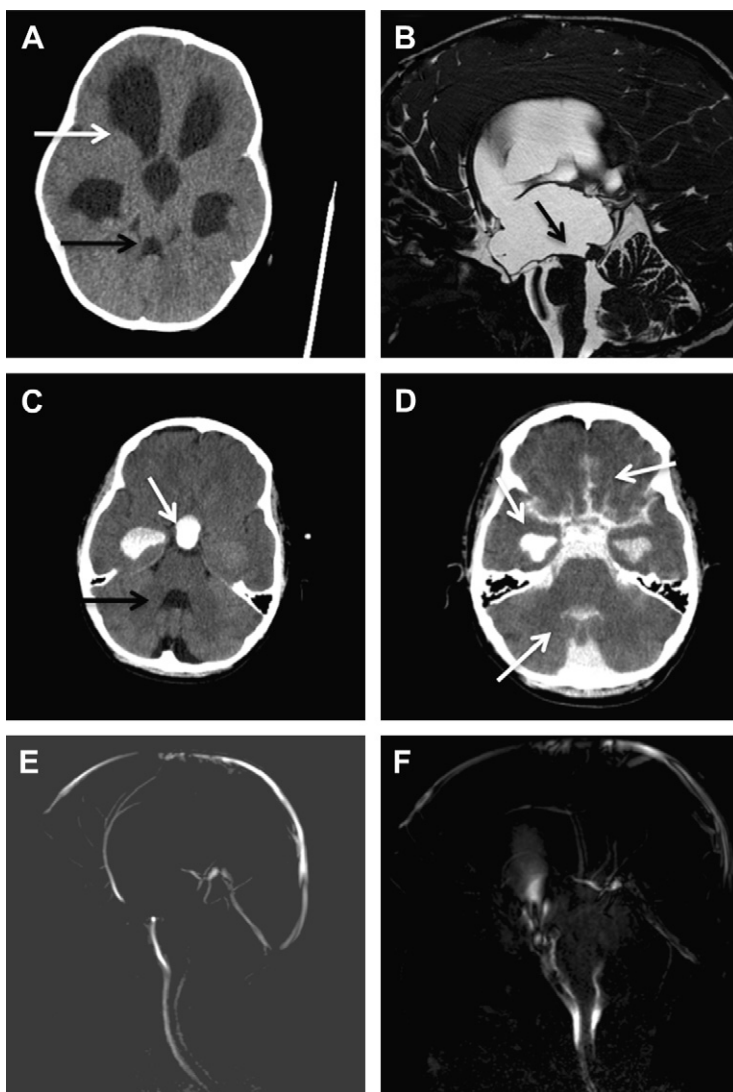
Imaging workup of CSF disorders. In aqueductal stenosis (A), a head computed tomography (CT) scan shows significant lateral and third ventricular dilatation proximal to the obstruction, with a normal-sized fourth ventricle. High-resolution magnetic resonance imaging (MRI) using a constructive interference in the steady-state (CISS) sequence (B) produces an image with excellent CSF-to-brain contrast demonstrating the branches of the basilar artery and abnormal aqueductal membrane. Head CT following intraventricular instillation of iodinated contrast, in this patient with obstructive hydrocephalus due to aqueductal stenosis (C), demonstrates entrapment of contrast material within lateral and third ventricles with no contrast within fourth ventricle or subarachnoid CSF spaces. Following endoscopic third ventriculostomy (ETV) in the same patient, head CT following intraventricular injection of iodinated contrast shows presence of contrast within all CSF spaces, including the prepontine cistern and subarachnoid space (D). Before ETV, cine phase contrast MRI showed absence of flow in the aqueduct (E). Following ETV (F), the cine sequence shows flow through the third ventricular floor, indicating ventriculostomy patency.
